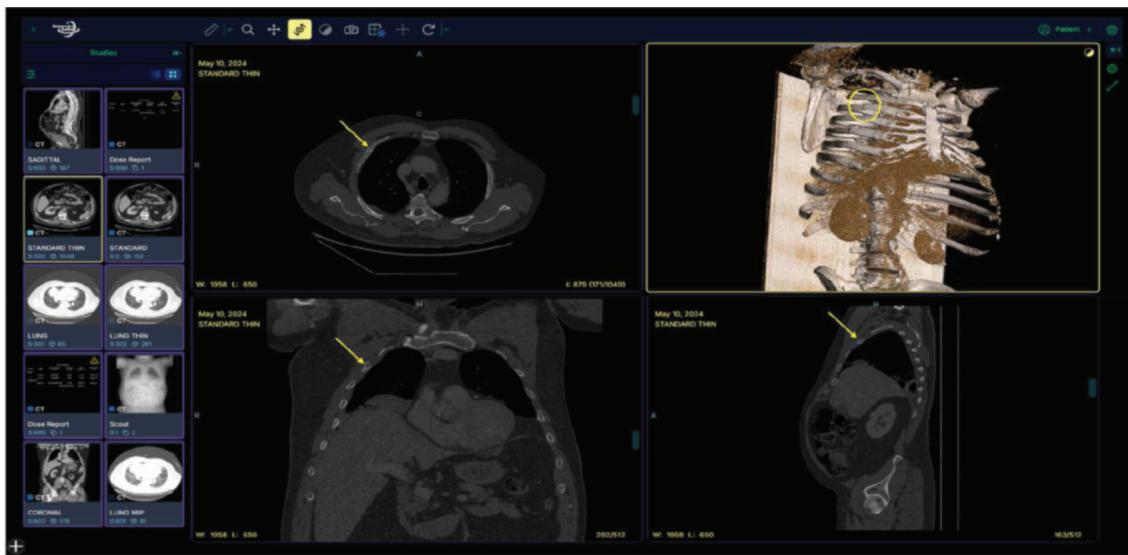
CT abdomen and pelvis (trauma), with and without contrast images demonstrating a mildly displaced fracture of the second rib, laterally as seen on CADAVIZ
